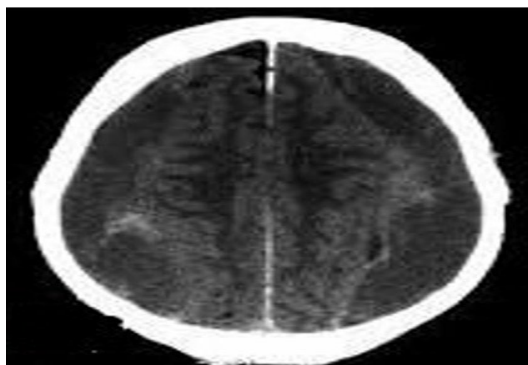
Native CT scan showing bilateral CSDH with membrane formation.
